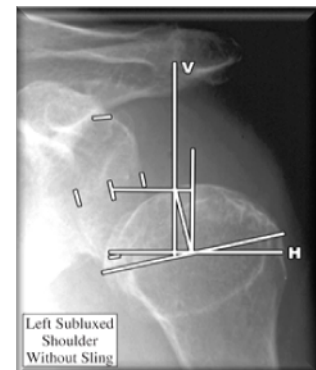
X-ray image of shoulder subluxation showing a large gap between the humeral head and shoulder socket. [5]
